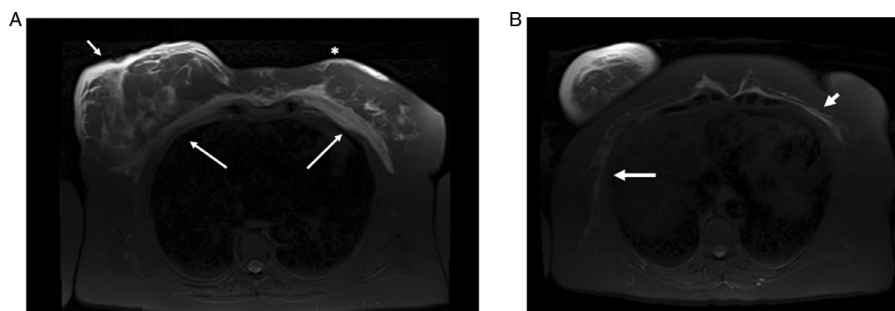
(A): T2W MRI confirmed the right unifocal level one axillary mass (white arrow). (B): Dynamic post contrast fat saturated breast MRI with no suspicious enhancement identified in the breast.
